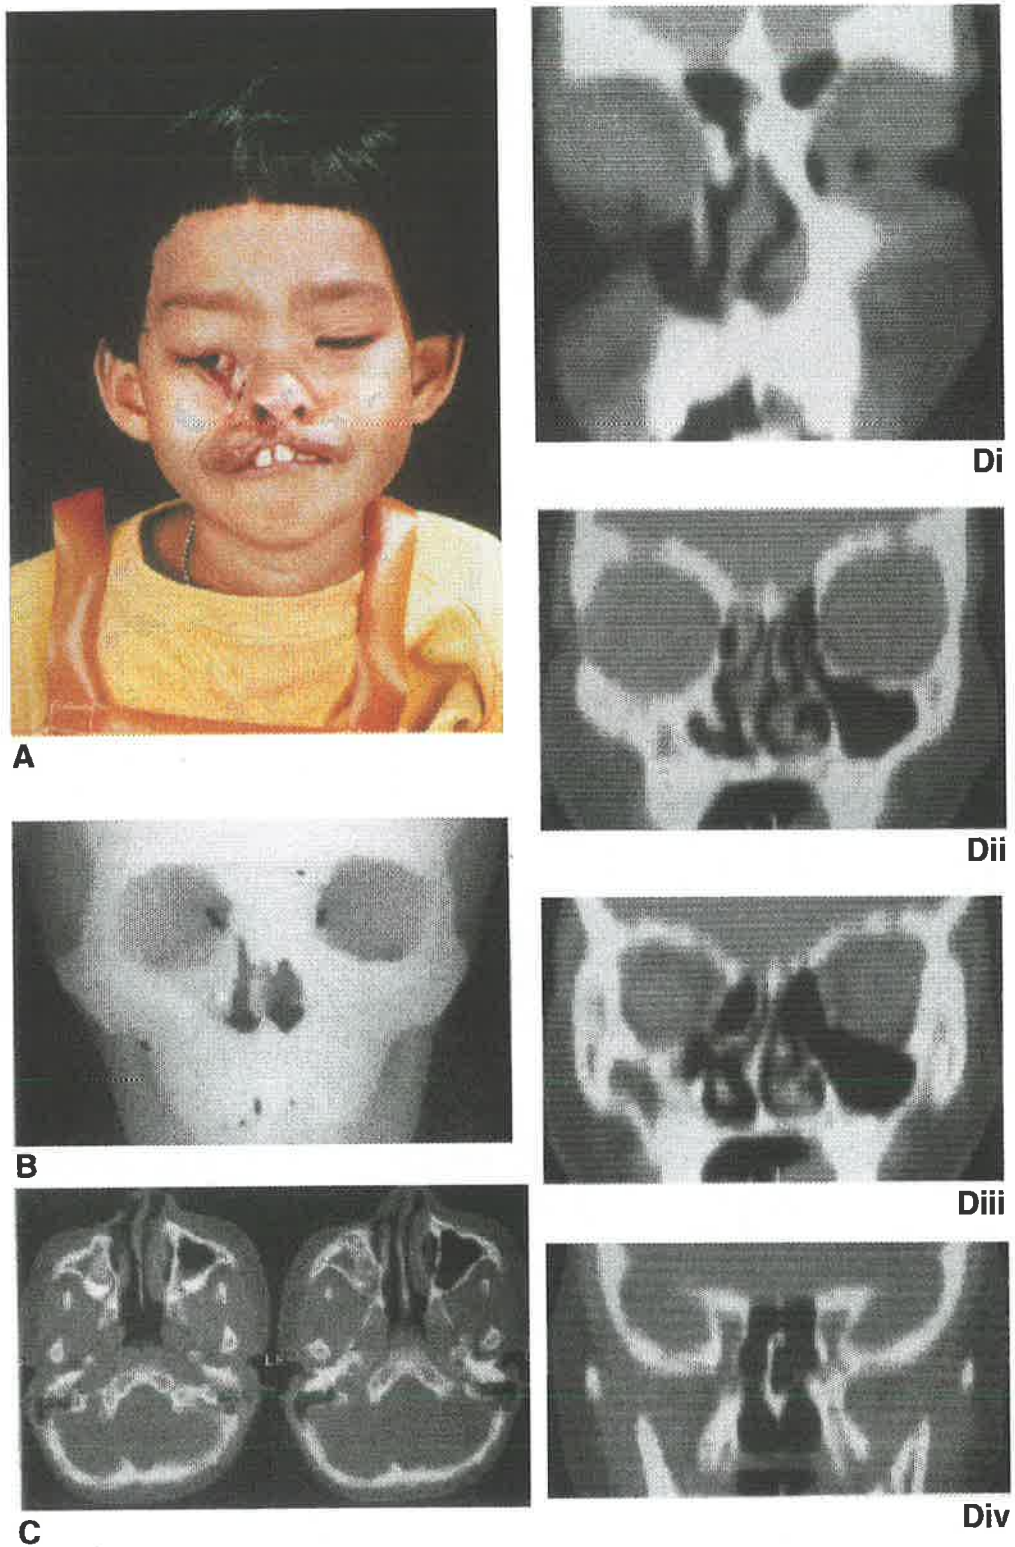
A. Seven-year-old Thai girl with an isolated unrepaired right-sided Tessier Number 3 cleft. B. Three-dimensional CT reconstruction shows the anatomy of the skeletal Number 3 cleft. C. Axial two-dimensional CT scan demonstrates the hypoplastic cleft right maxilla with associated relative absence of pneumatization. D. Sequential coronal two-dimensional CT reformats trace the clefting process through the anteroposterior extent of the midface (i-iv).
